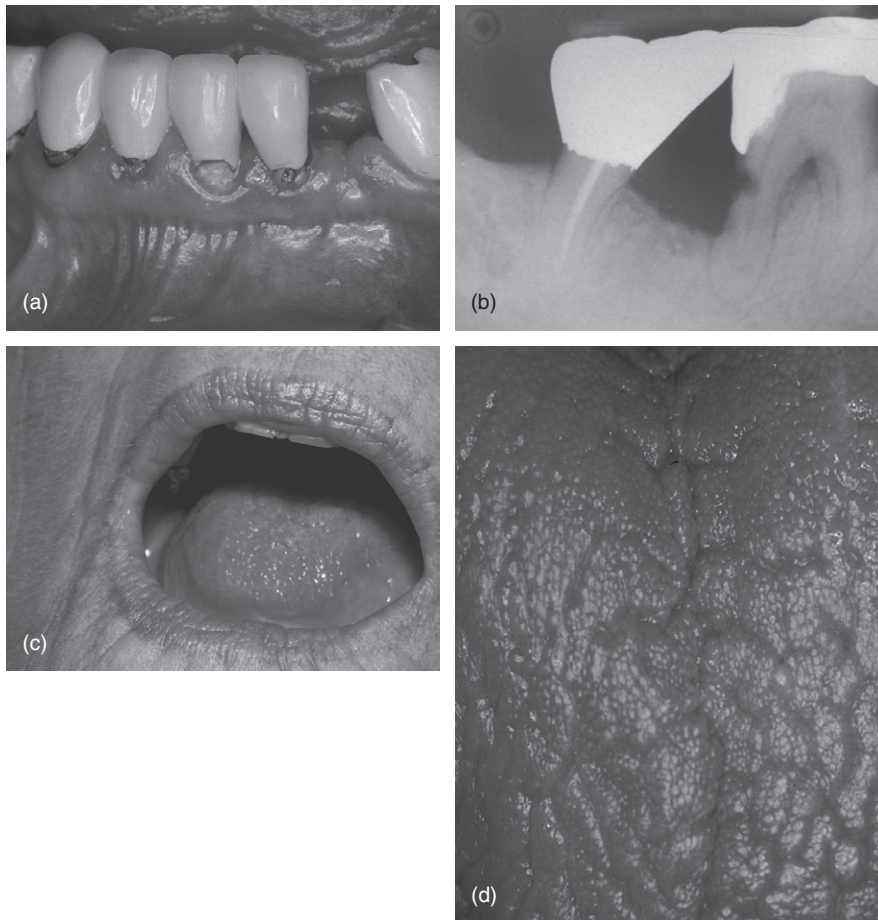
(a and b) Clinical and radiographic evidence of recurrent dental caries and (c) dry lips and (d) tongue in a patient with chronic salivary gland hypofunction.
